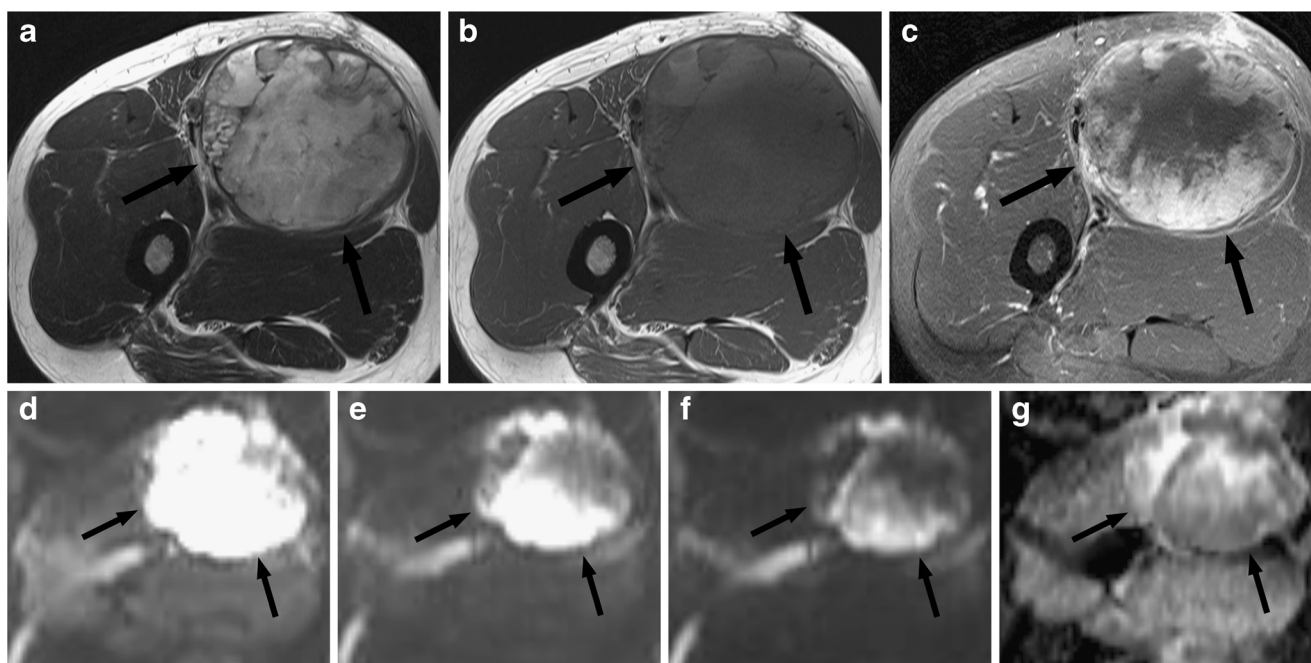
A 65-year-old man with leiomyosarcoma in the thigh, correctly interpreted as malignancy (score 4) during the first and the second steps by both readers. On quantitative analysis of DWI, ADC_{min} correctly suggested malignancy, whereas, ADC_{av} incorrectly suggested benignity due to large necrosis. (a, b) There is an intramuscular mass (arrows) in the anterior compartment of the thigh, which shows heterogeneous signal intensity with large necrosis on T2- (a, TR/TE 5584/68) and T1-weighted images (b, 681/11). (c) Fat-suppressed contrast-enhanced T1-weighted image (736/11) shows intense enhancement and a large central non-enhancing area (arrows). (d, e, f) Diffusion-weighted images
